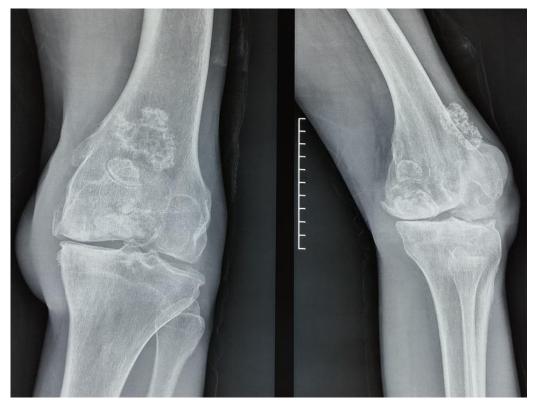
x-Ray of the left knee, front and profile, showing multiple radiopaque ossified lesions on the medial aspect of the left knee.
